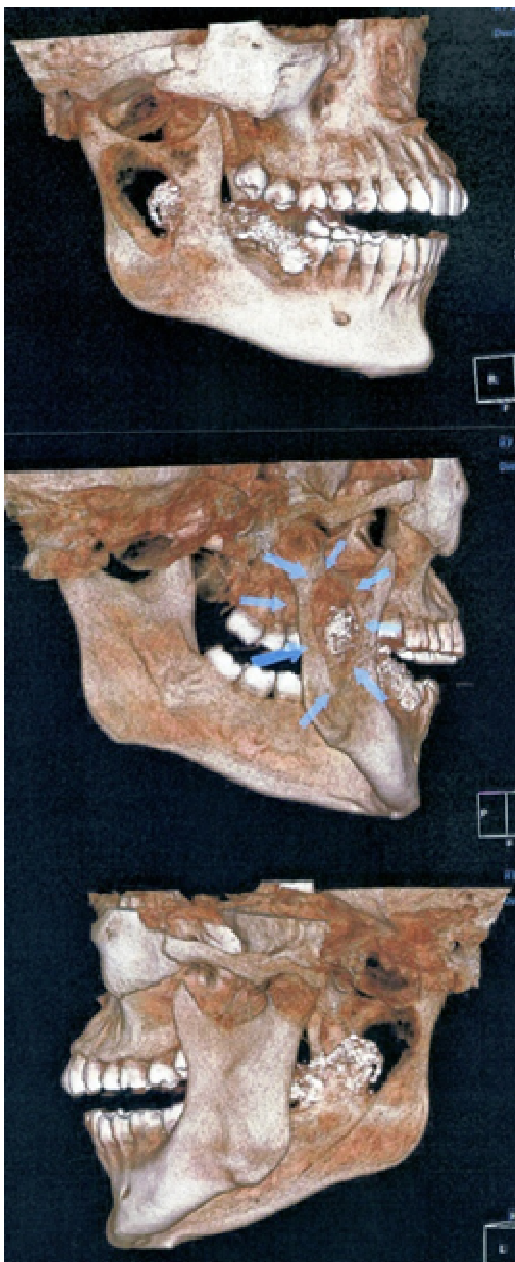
Pre op CBCT images
